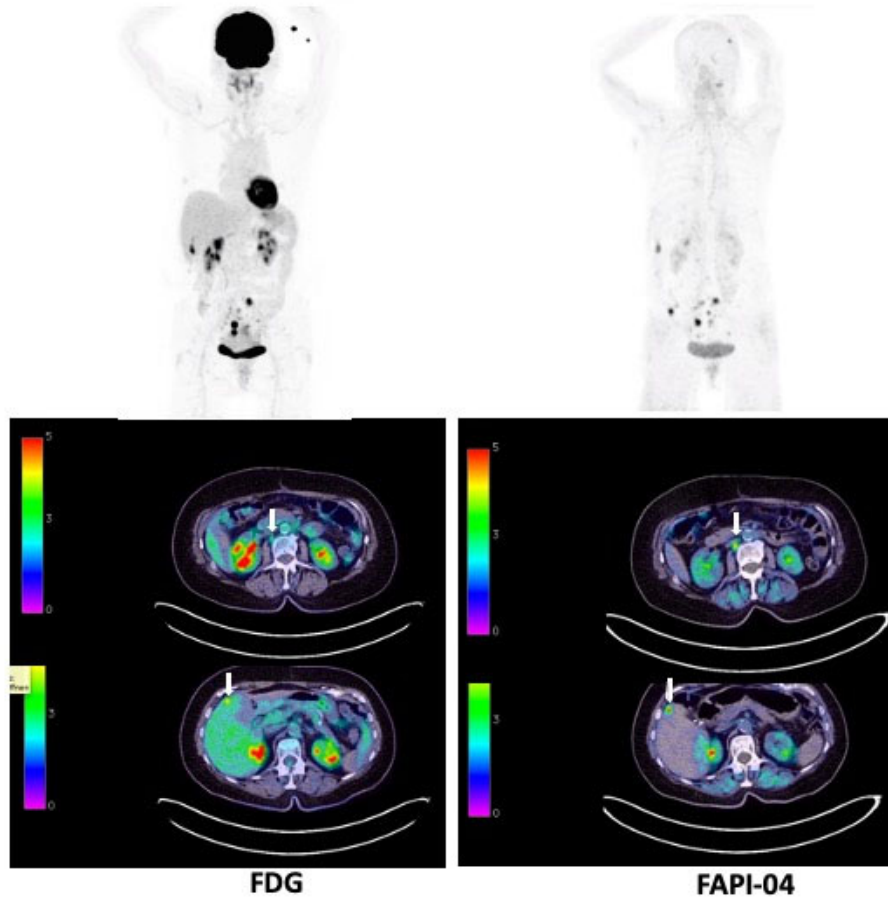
Comparison of FDG-PET/CT and FAPI-46-PET/CT in a patient with metastasized ovarian cancer. Maximum intensity Projections (MIP) and transaxial slices at 1 h p.i. The metastatic lesions in liver and lymph nodes are better seen with FAPI (white arrows).
